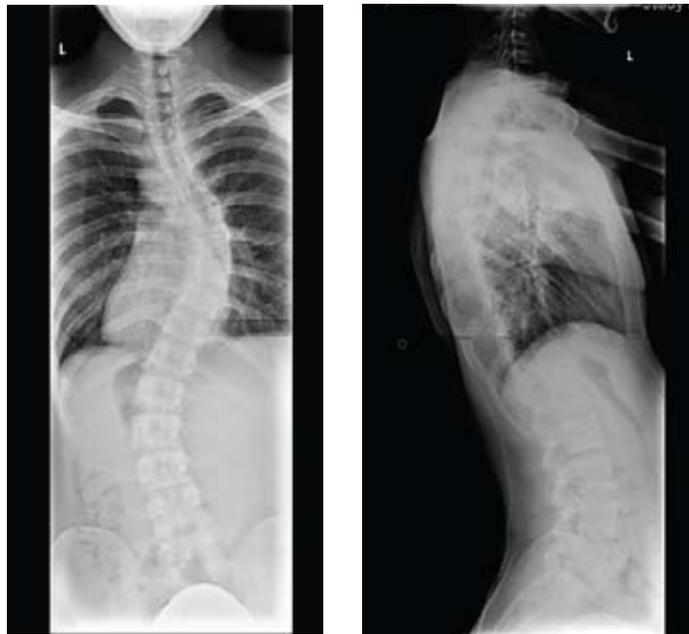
Preoperative AP and lateral 36 x 14 scoliosis X-rays of triple major idiopathic scoliosis. Lateral film shows fixed thoracolumbar kyphosis secondary to disc degeneration.
